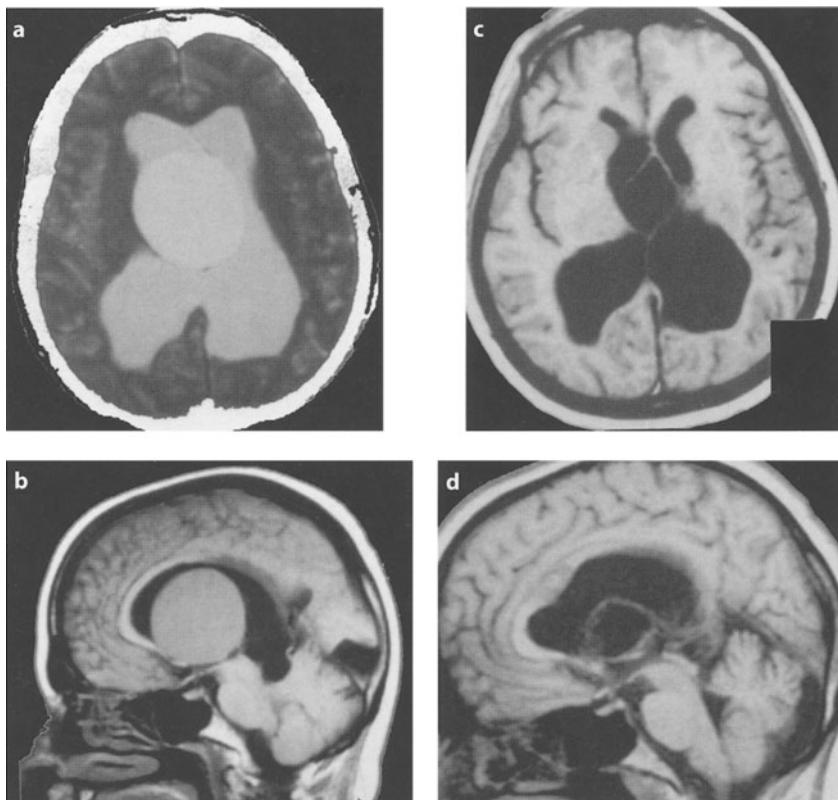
The largest colloid cyst of our series. Preoperative MRI: a axial, b sagittal views. Postoperative MRI (at 1 year): c axial and d sagittal views
